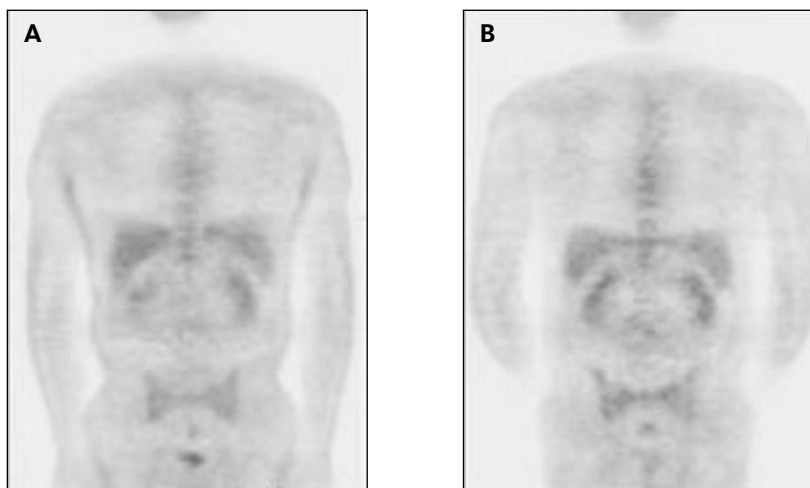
This 46-year-old HIV-positive man who had been treated with HAART for 30 months developed lipodystrophy. PET showed markedly increased subcutaneous FDG-uptake in the thoracic, abdominal and pelvic areas (Figure 1A). In this patient antiretroviral therapy was adjusted which resulted in a slight subjective improvement. FDG-PET 6 months after switching of therapy was completely normal without any evidence of increased subcutaneous FDG-uptake (Figure 1B).
